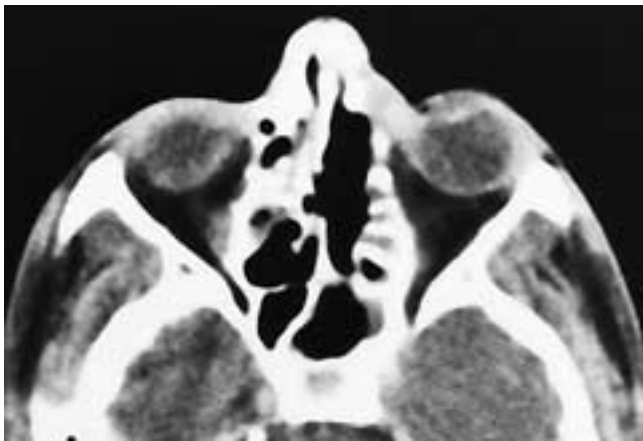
Axial CT scan shows the appearance of a left ethmoidectomy. Several of the posterior and more cranial ethmoid septae are still seen. This is a common finding, and these areas may be sites of residual disease.
